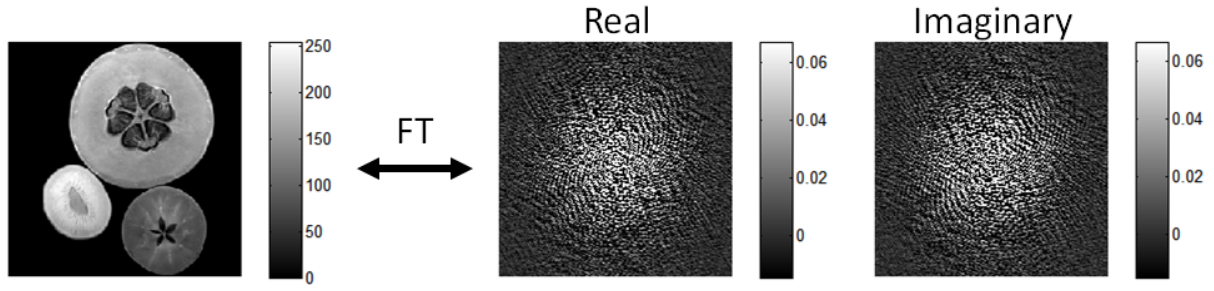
MRI image and corresponding k-space images (real and imaginary components). For visualization purposes the maximum value of the k-space color-scale was lowered, given that the amplitude of the center elements (low frequencies) are considerably higher than the rest of the k-space.
